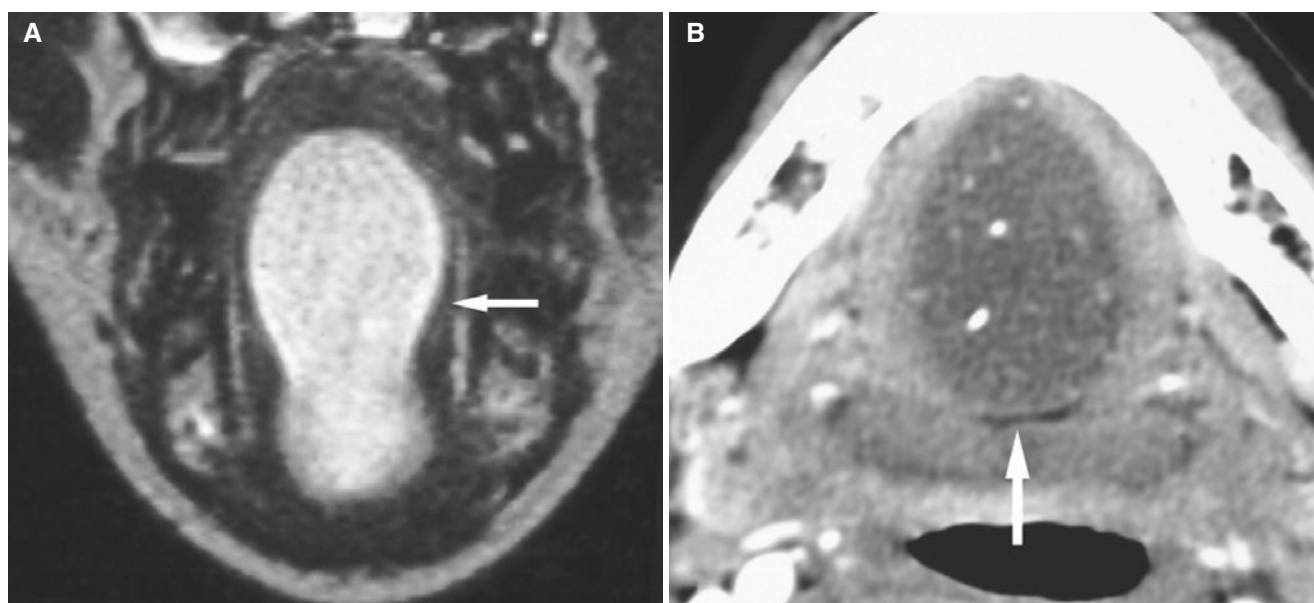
Dermoid cyst, sublingual space and tongue; 25-year-old female with sublingual swelling. (A) Coronal STIR MRI shows high-signal mass with smooth delineation (*arrow*). (B) Axial CT image shows cyst (*arrow*) with multiple calcifications
